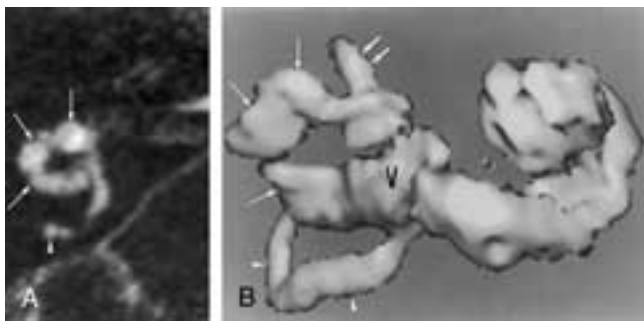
Enlarged lateral semicircular duct. A, Axial 0.7 mm thick T2-weighted gradient echo image through the right inner ear. A fluid-filled thickened lateral semicircular duct can be seen (long white arrows). Compare this with the normal thickness of the posterior semicircular duct (white arrowhead). B, Three-dimensional virtual image of the right membranous labyrinth, made by using 0.7 mm thick T2-weighted gradient-echo images. The irregular and enlarged lateral semicircular duct can be recognized (long white arrows). The superior (small white arrows) and posterior (white arrowheads) semicircular ducts have a normal size. V, vestibule.
